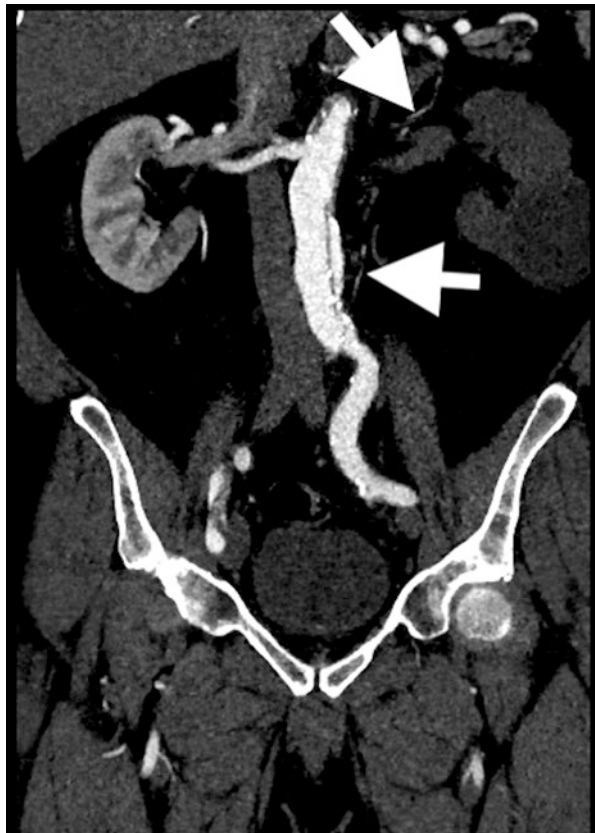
CT angiography images showing two different reconstructions of a patient with an abdominal dissection tear. The left renal artery was adjacent to the false lumen. The lack of contrast in the left kidney is compatible with hypoperfusion
